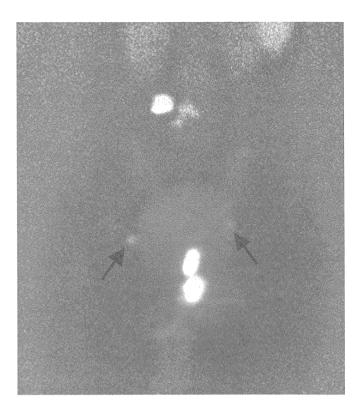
Lymphoscintigraphy taken prior to the operation (case 7). Peritumoral injection of technetium-labeled tin or sulfur colloid followed by lymphoscintigraphy shows accumulation of radiotracer to external iliac lymph nodes (arrows), regional lymph nodes of perineal rhabdomyosarcoma (RMS).
